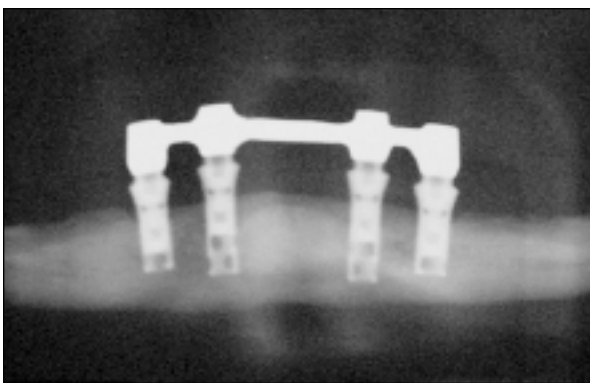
Orthopantomogram of two 8-mm hollow-cylinder implants in the medial positions and two supporting 6-mm hollow-cylinder implants in the interforaminal region of the mandible. Because of the slanted lingual aspect of the mandible, longer implants would have led to perforation of the lingual cortical bone.
